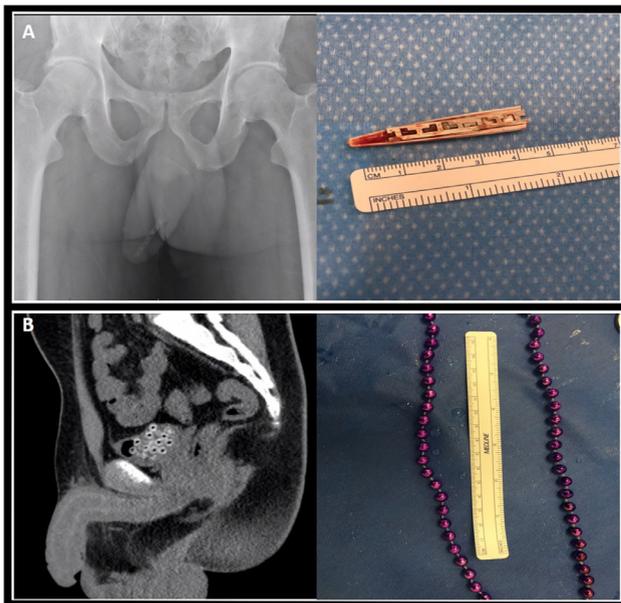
Retrieved genitourinary foreign bodies: (A) pelvic radiographic imaging revealing plastic spoon fragment affixed to a razor blade which was found within the distal penile urethra and was successfully managed with manual extraction. (B) CT imaging (sagittal plane) revealing a beaded necklace which was found within the urinary bladder and was successfully managed with cystoscopic extraction. (Color version available online.)
